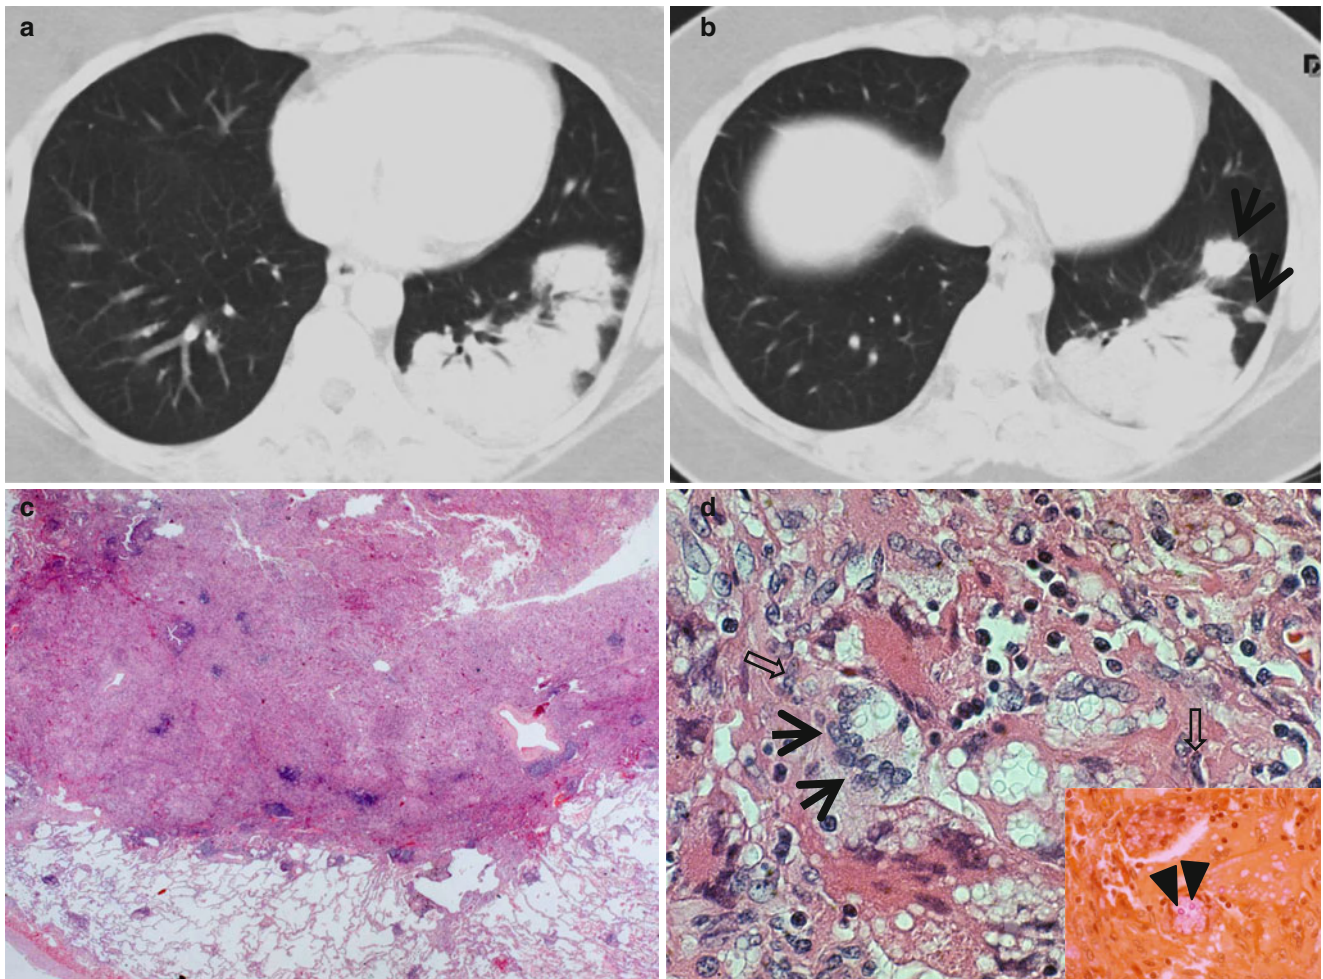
Pulmonary cryptococcosis appearing as localized consolidation or nodule in a 34-year-old immunocompetent woman. (a, b) Lung window images of CT scans (5.0-mm section thickness) obtained at levels of the cardiac ventricle (a) and liver dome (b), respectively, show large area of consolidation and several poorly defined nodules (arrows in b) in the left
